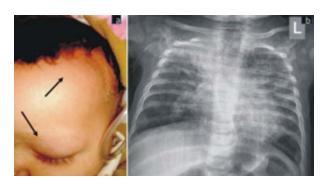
Alopecia over left fronto-parietal region and loss of eyebrows (arrows) (a); chest X-ray (anteroposterior view) showing interstitial pattern of infiltrates in both lungs, predominantly perihilar. Homogenous opacity in right upper lung fields and absent thymic shadow (b).
